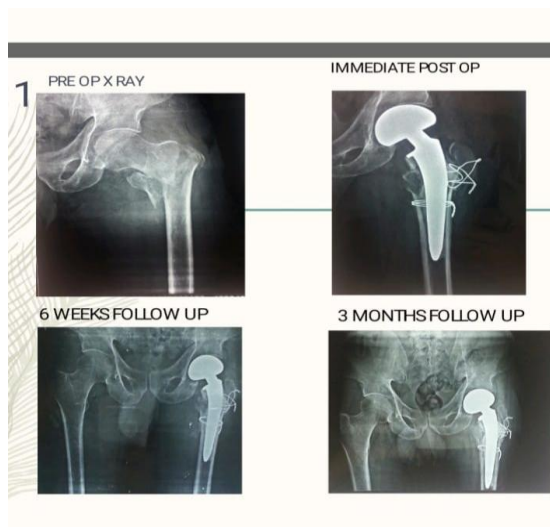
case 1, 2 pre-operative X ray and post-operative x-ray, 3- & 6-month follow-up x ray
